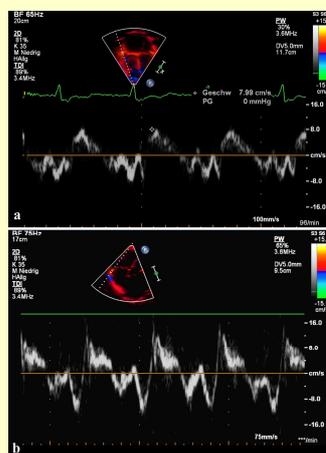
Apical 4-chamber view. The white broken line indicate M-Mode cursor placement at the tricuspid lateral annulus. Representative image of the tissue Doppler measured TAPSV in a 18 year old PAH-CHD patient (Figure 1a), and in a 16 year old healthy adolescent (Figure 1b).
